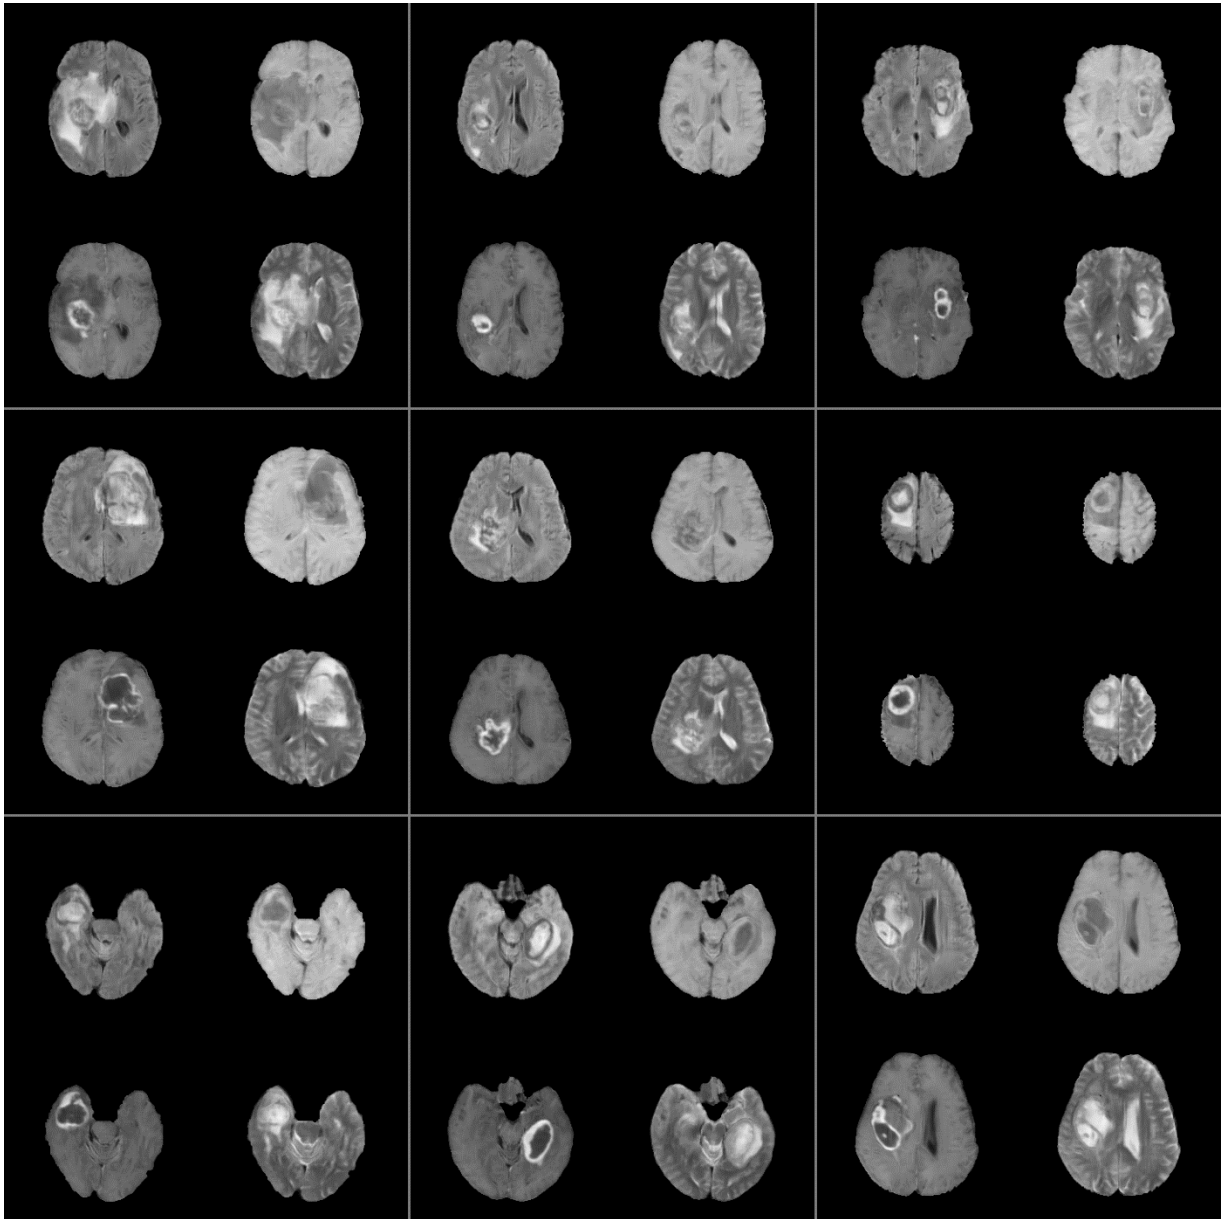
Axial view of 9 synthesized samples. Each sample shows 4 MRI sequences.
